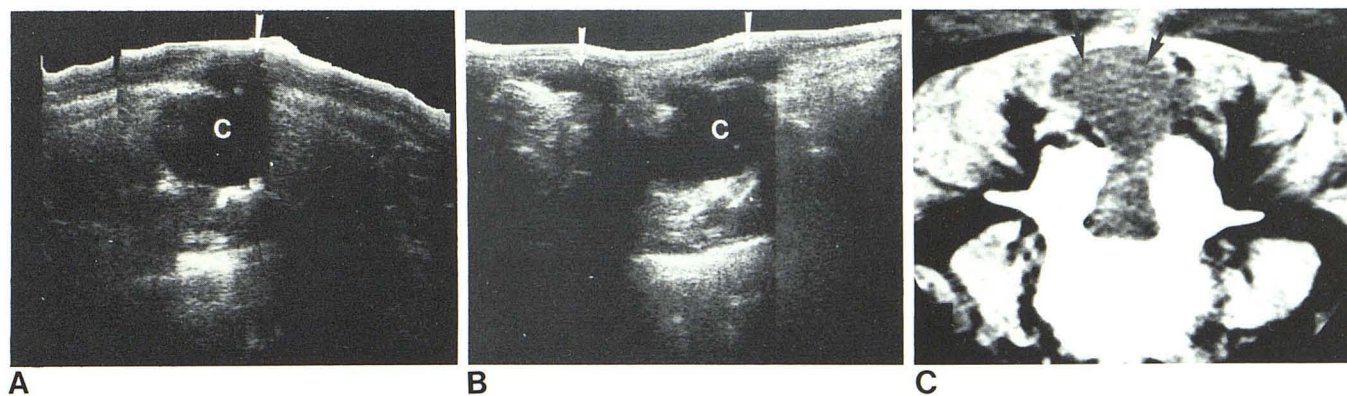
A, Transverse sonogram in prone position shows largest deep cyst (C), which communicates with smaller, more peripheral cyst (arrow). B, Sagittal sonogram shows three components with largest deep cyst and smaller cysts
